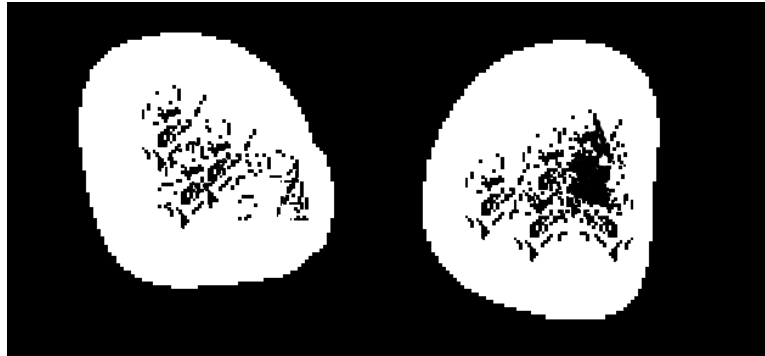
A slice of DCE-MRI after Otsu thresholding
